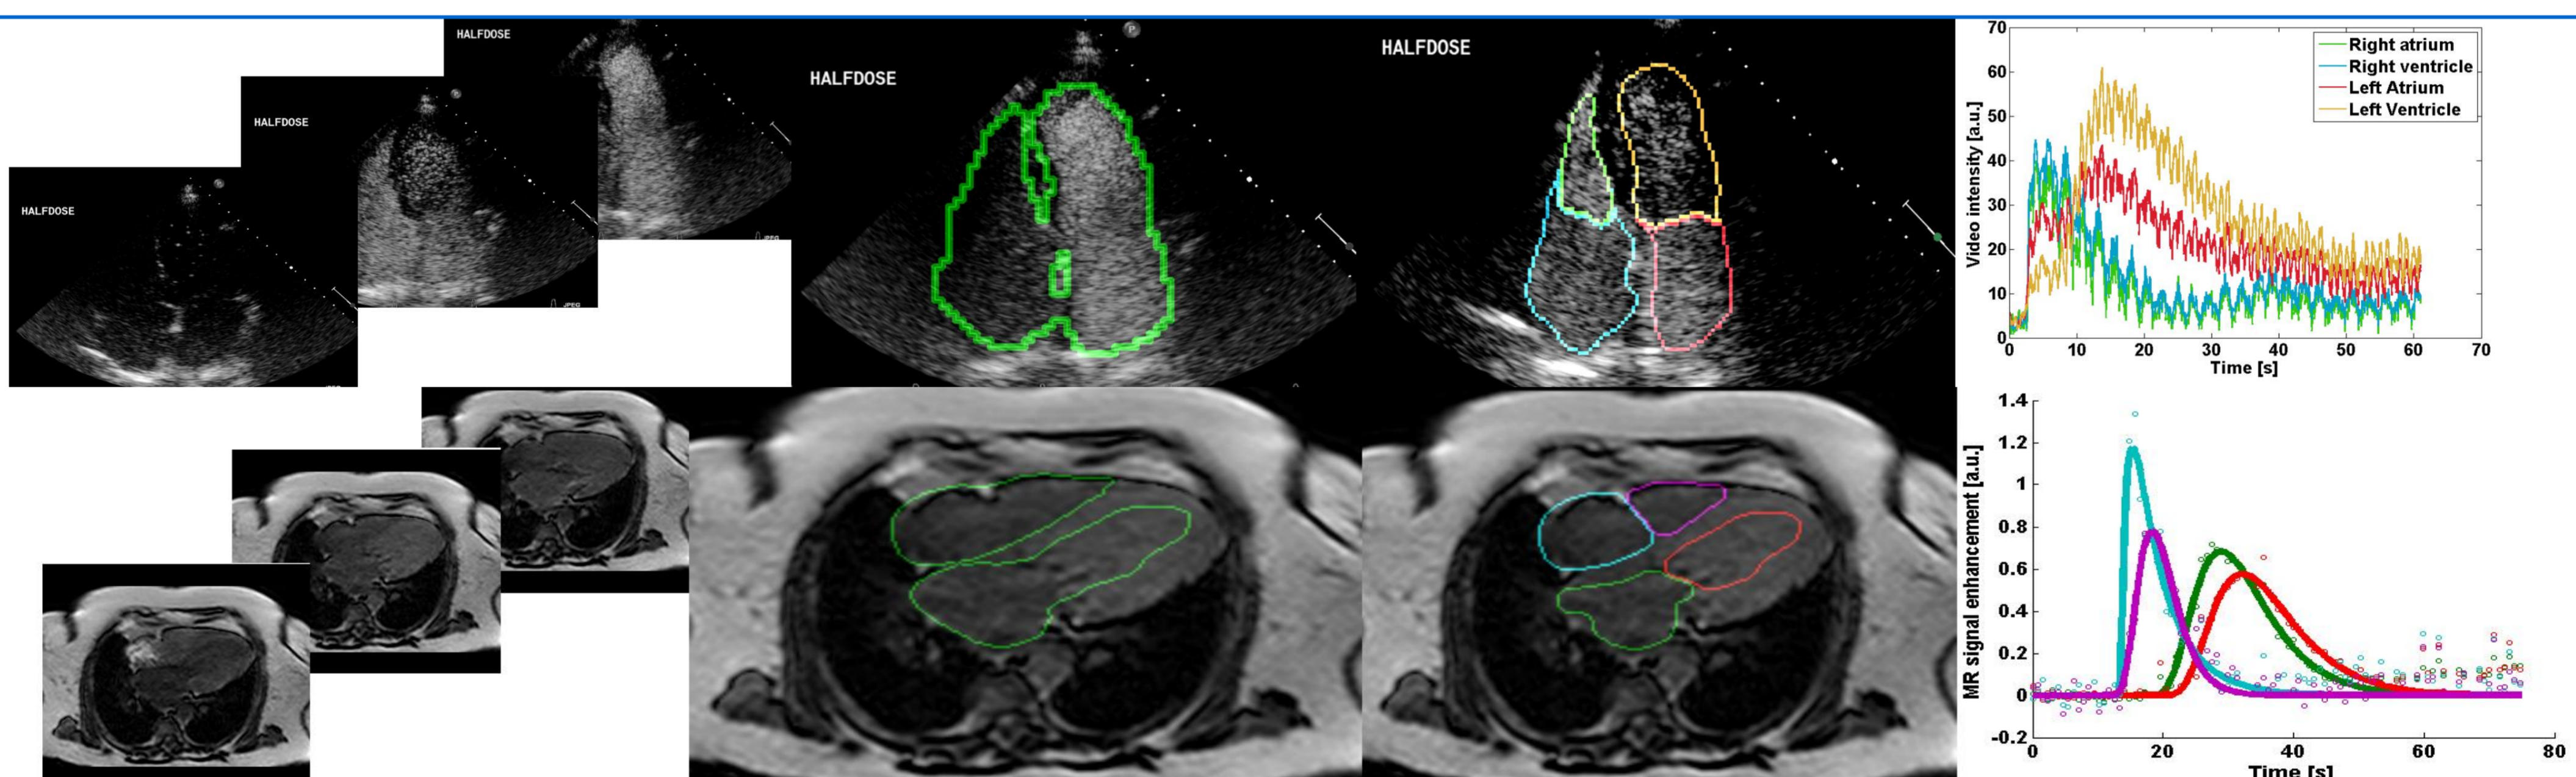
From top left to right: sample images from a CE-US recording; detection of areas of contrast agent passage; ROI obtained by clustering of the individual IDCs; signal intensity versus time obtained averaging the image intensities in the identified ROIs. Bottom row: similar results for DCE-MRI.
